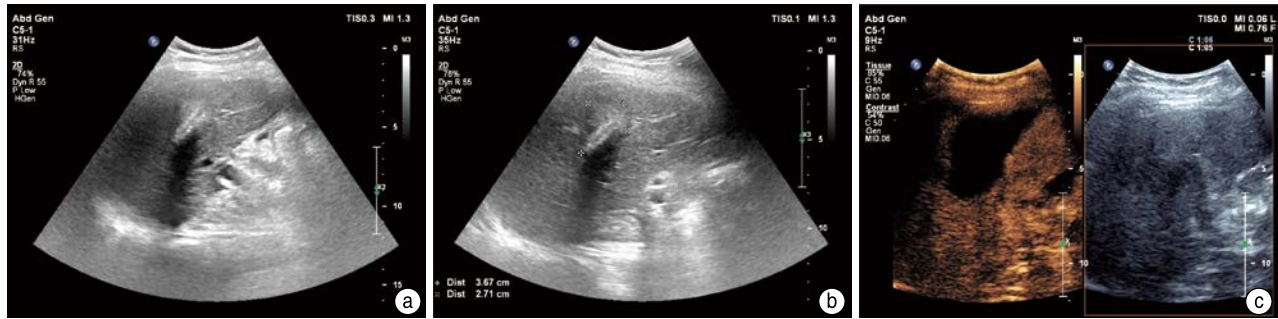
(a) The lesion was located Segment III of the liver; (b) Two-dimensional sonogram of the lesion after No Touch hepatic pedicle microwave ablation; (c) Postoperative contrast-enhanced ultrasonography showed no contrast agent filling in Segment III of liver
